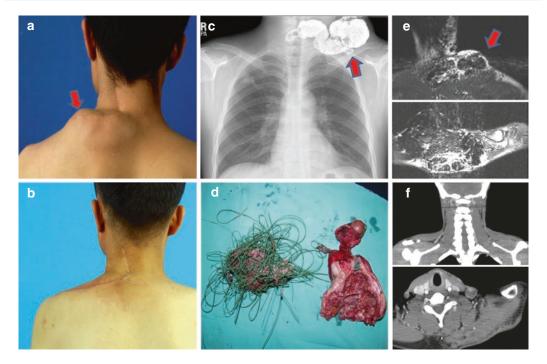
CC: pulsating mass on the left lower neck. Dx: Arteriovenous malformation. (a) preop picture. (b) postop picture. (c) coil embolization. (d) op finding: AVM mass and coil within the mass. (e) preop MRI. (f) postop CTA
